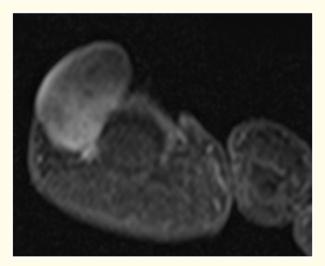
Sagittal views of the lesion on MRI.
